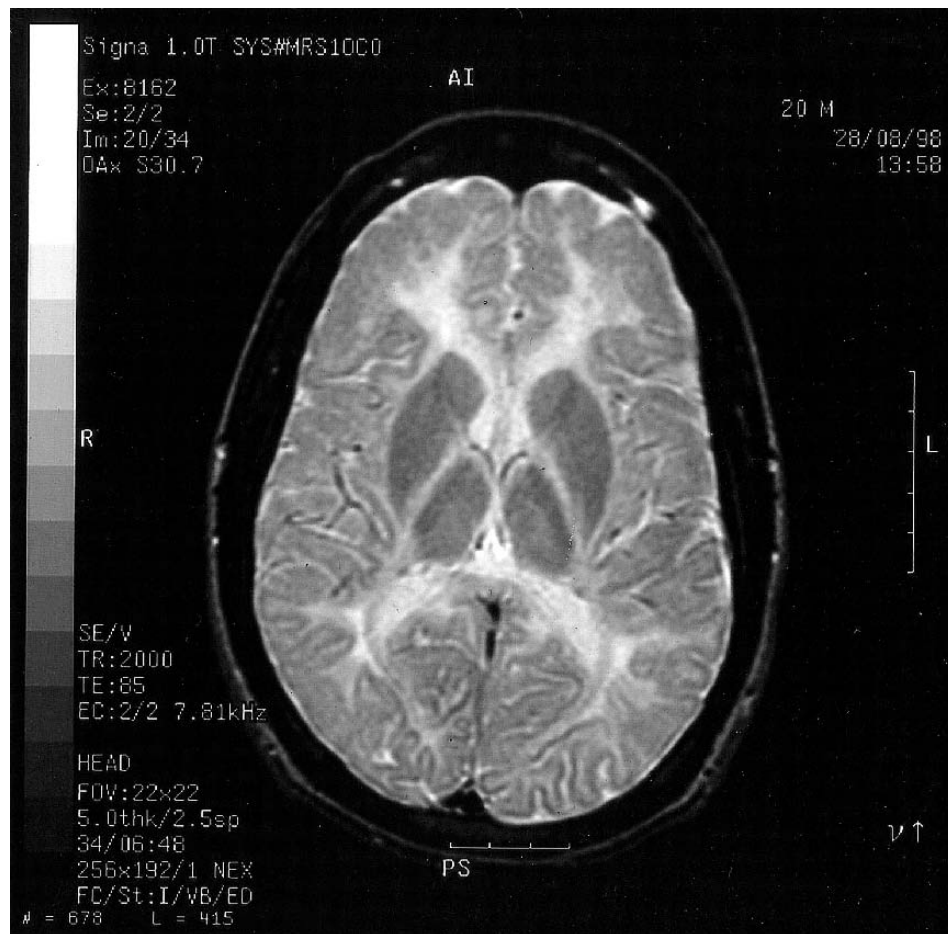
Magnetic resonance image in PMD. This T2-weighted image was obtained at the age of 20 yr from the second patient in this review (Fig. 3). The abnormally high signal in the white matter and the posterior internal capsule is due to high water content. The relatively low signal intensity in the anterior internal capsule suggests the accumulation of some mature myelin. The mottled appearance of the frontal white matter may represent islands of myelination.
